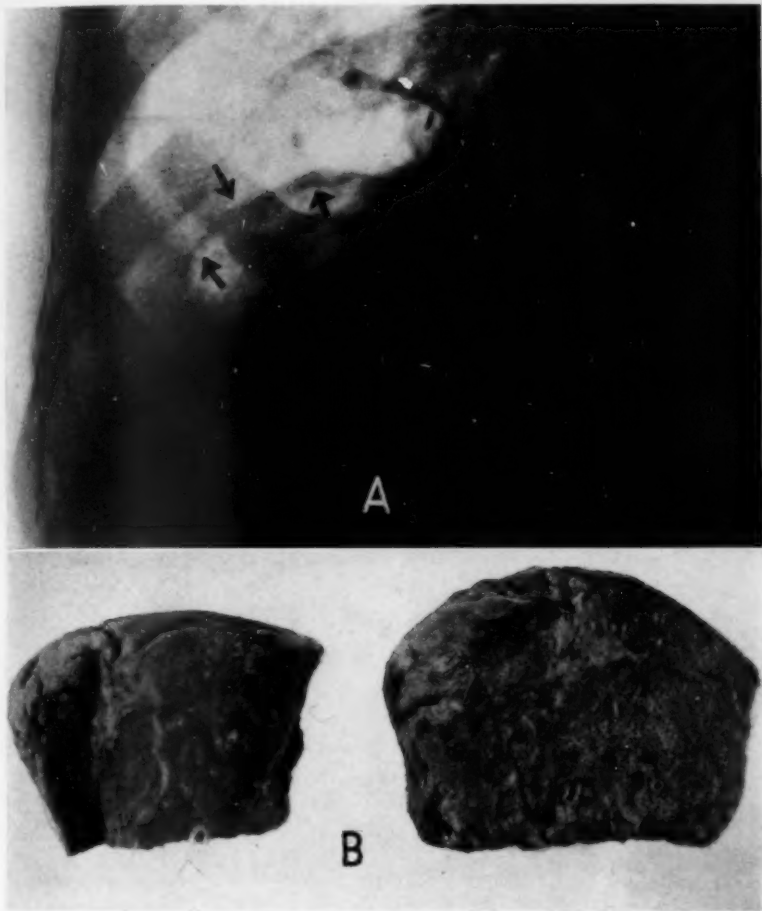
A*, roentgenogram showing the linear shadow (note arrows) produced by the healed infarct demonstrated in figure 1. *B*, photograph of two healed infarcts. Note the characteristic pleural dimpling, the dilated bronchi within the lesion and the adjacent compensatory emphysema.
